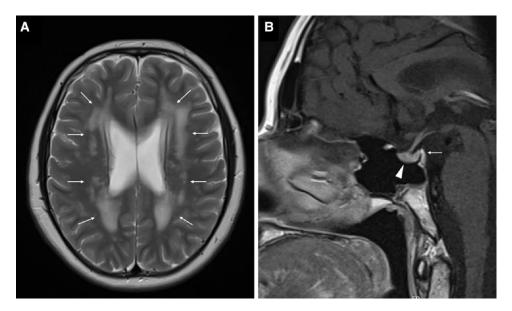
Brain and sellar magnetic resonance imaging of the brother. (A) Axial T2-weighted section shows extensive white matter lesions in both cerebral hemispheres (white arrows). (B) Midsagittal T2 fluid attenuated inversion recovery image shows a small and heterogeneous anterior pituitary (arrowhead) and hypoplastic posterior pituitary (white arrow).
